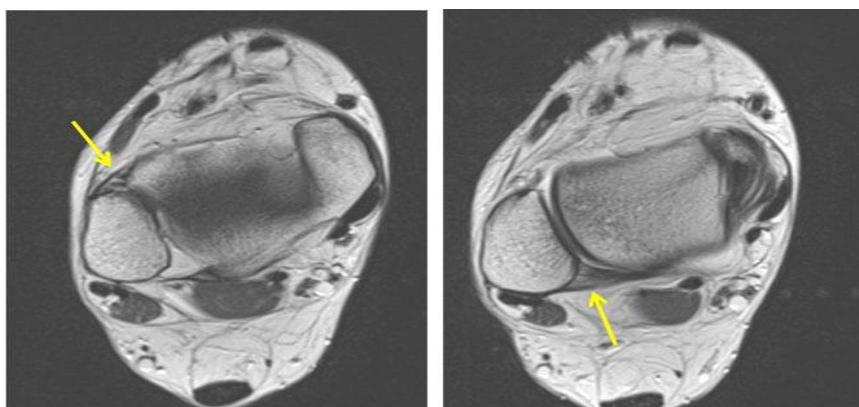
MRI of lateral aspect of the ankle. a) ATFL is identified by the yellow arrow; b) PTFL is identified by the yellow arrow⁽¹¹⁾.
